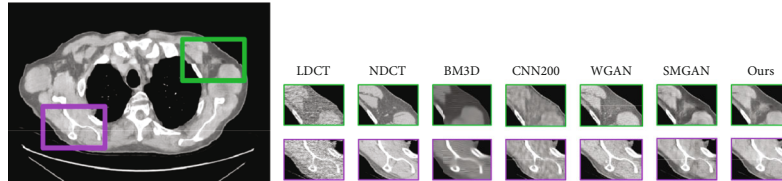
Denoising results of the different algorithm on the lung CT images dataset. From left to right, the subgraph indicates the detail of different images: the low-dose CT (LDCT), normal-dose CT (NDCT), BM3D, CNN200, WGAN, SMGAN, and our framework.
